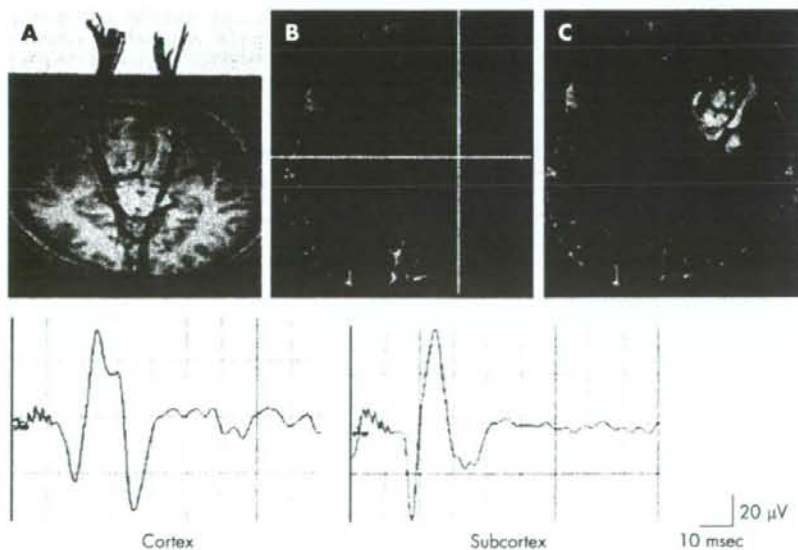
Patient No 4 had a left fronto-parietal glioblastoma multiforme. (A) Preoperative fibre-tracking identified symmetrical pyramidal tracts (red lines) from the cortex to the cerebral peduncles. (B) Brain T2 weighted MRI revealed a hyperintense area in close proximity to the left pyramidal tract, identified by fibre-tracking (red). Cortical stimulation of the left precentral gyrus, which had been defined by a somatosensory evoked potential, elicited a motor evoked potential (MEP) in the right abductor pollicis brevis muscle (Cortex). During removal of the tumour, subcortical stimulation elicited MEPs at the bottom of the tumour (intersection of the yellow lines in the intraoperative navigation image), 1 cm from the edge of the predicted pyramidal tract (red) (Subcortex). To avoid causing additional neurological deficits, no further removal was performed. (C) Postoperative T2 weighted MRI demonstrated preservation of the pyramidal tracts identified by fibre-tracking (red).
